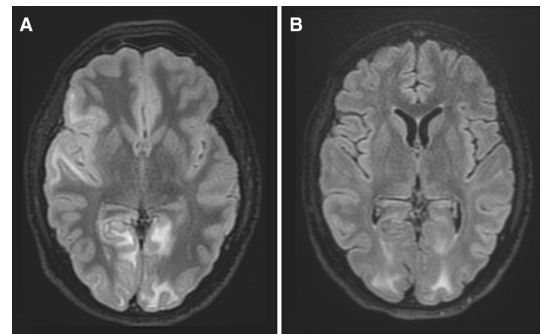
Axial T2 FLAIR brain MRI on admission and after chelation therapy. Brain MRI on admission showed a T2 FLAIR hyperintensity involving the right insular cortex and the bilateral temporal and occipital white matter, related to vasogenic oedema (A). The control of T2 FLAIR MRI after initiation of chelation therapy revealed a partial regression of the cortical and subcortical abnormalities (B).
